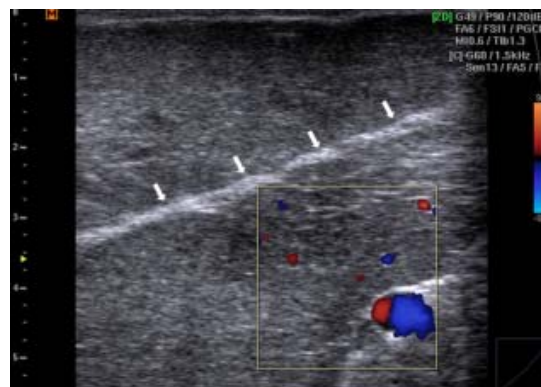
Sagittal ultrasound scan of udder parenchyma in lactating Jenny demonstrating a homogeneous coarse granular hypoechoic right and left halves separated by hyperechoic septum (arrows).
